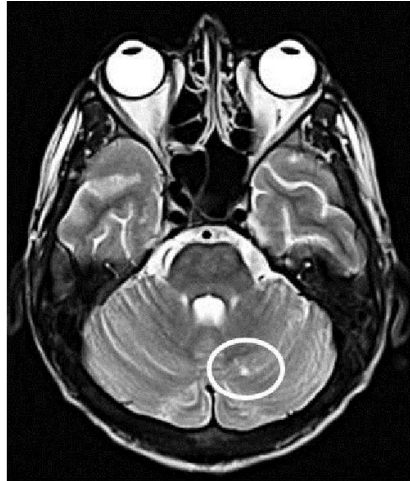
21):Describe Acute left cerebellar stroke which appear as hyper-dense lesion on T2 weighted MRI of the brain(encircled)https://www.researchgate.net/figure/Acute-left-cerebellar-stroke-hyper-dense-lesion-on-T2-weighted-MRI-of-the-brain_fig1_280787949
